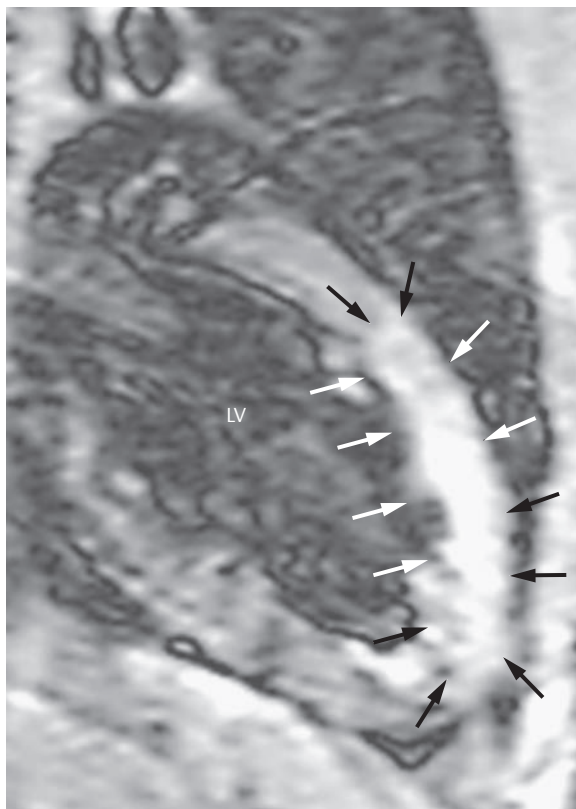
Acute myocarditis. Cardiac MRI of a 16-year-old boy with acute retrosternal pain, intermittent right bundle branch block, and elevated troponin. The T2w STIR sequence clearly depicts the elevated signal intensity (arrows) at the anterior wall and apex of the LV as an expression of inflammatory edema.
